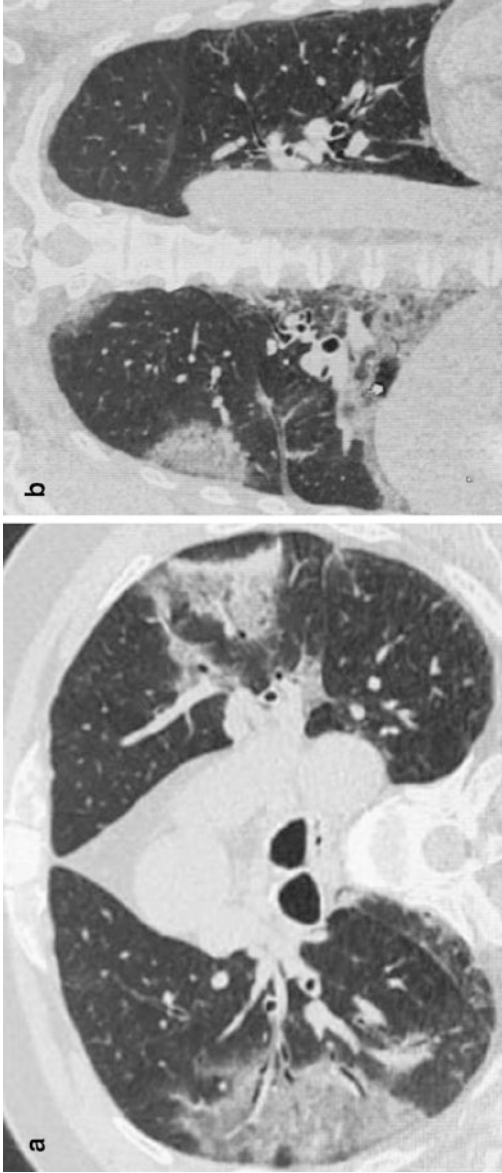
A 59-year-old male, known case of hypertension and diabetes, presented with complaints of fever, dry cough, and headache. CT scan chest (a, axial view and b, coronal view) shows peripheral patchy areas of ground-glass opacities with consolidation and fibrosis in both lungs
